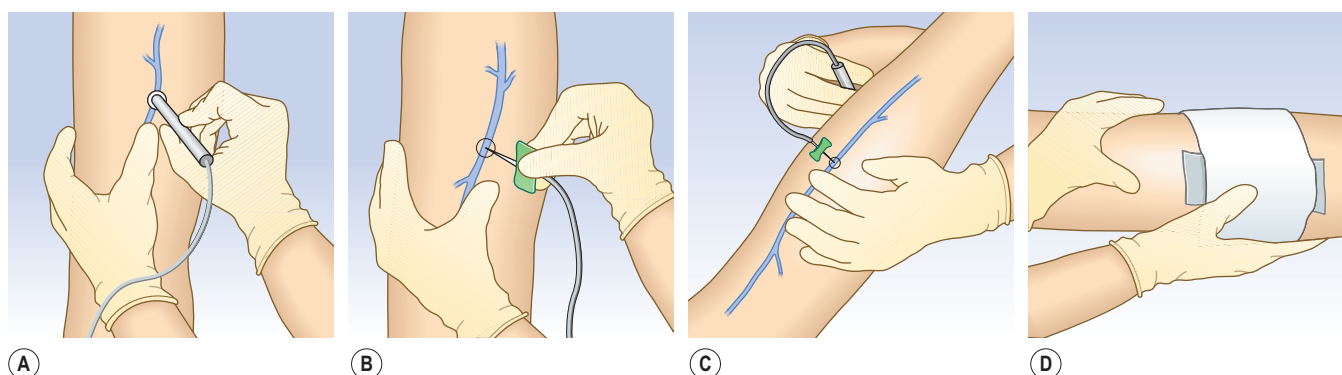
A, Localization of an incompetent perforator vein (IPV) through the use of a handheld Doppler device. B, Cannulation of the IPV with a 26-gauge butterfly needle. C, The leg is elevated 45 degrees, and 0.5–1.0 mL of sclerosing solution is placed into the now empty perforator vein under minimal pressure. Note placement of a finger distal to the injection site to feel for extravasation of solution (which would indicate improper placement of the needle and necessitate immediate discontinuance of treatment and infiltration of the injection site with lidocaine 1%). D, Immediate compression of the treated vessel with an STD foam pad and tape dressing.
